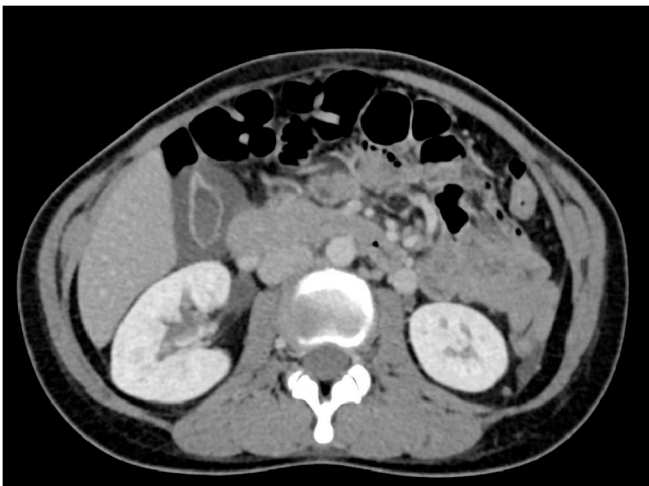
Computed tomography scan shows gallbladder wall thickening.
